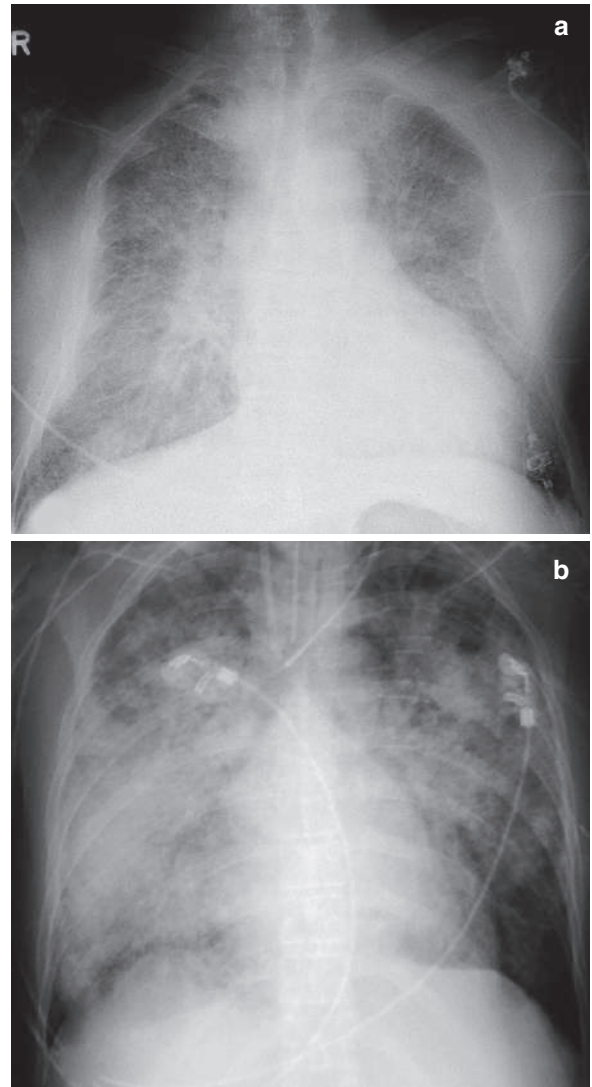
Anteroposterior plain chest radiographs in two different patients show bilateral symmetrical pulmonary edema with bat wings appearance in (a), and bilateral, almost symmetrical pulmonary hemorrhage in (b). Notice that without history, you cannot differentiate pulmonary hemorrhage from pulmonary edema based on radiographic presentation alone
